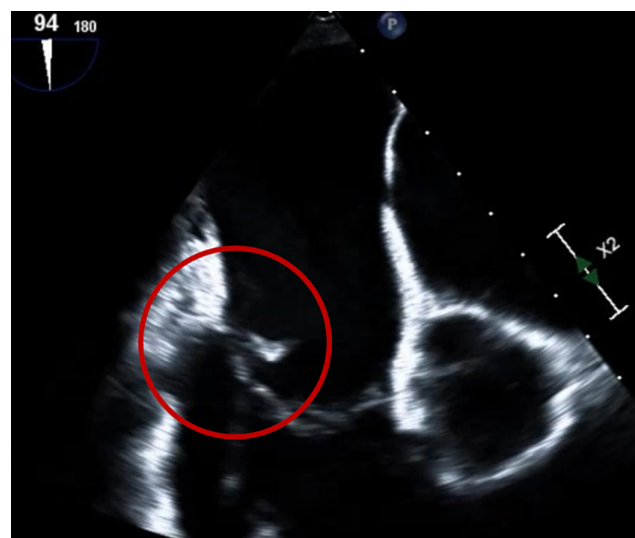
Transoesophageal echocardiography demonstrating a 0.9 × 0.4 cm vegetation on right atrial lead.
